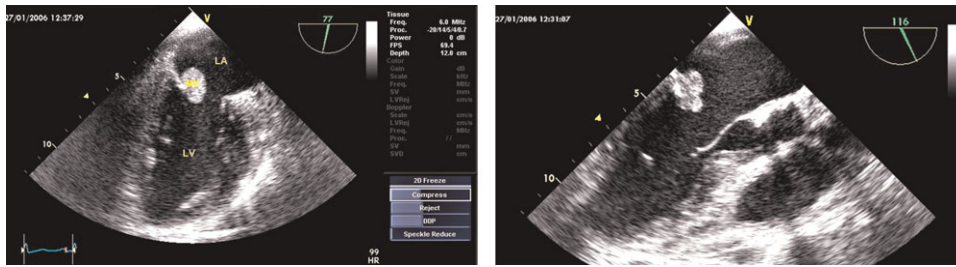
Two-chamber (left panel) and 120° (right panel) transoesophageal views showing a round, lobulated, homogeneous mass arising from atrial side of the posterior leaflet of the mitral valve.
